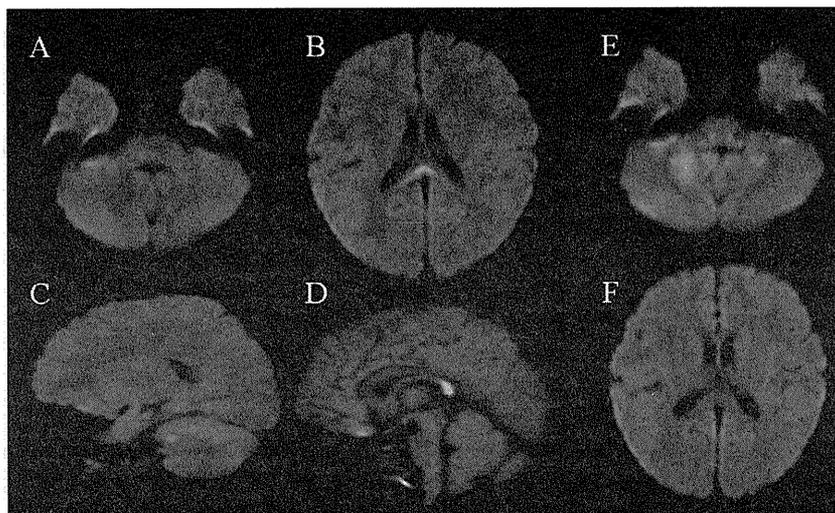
MRI findings in case 3. (A–D) Axial and sagittal DWI on day 1 showed hyperintensity in the splenium of the corpus callosum and small spotty lesions near the dentate nucleus. (E and F) Axial DWI on day 3 showed marked hyperintensity in the bilateral dentate nucleus and a disappearance of the high intensity signal in the splenium of the corpus callosum.
